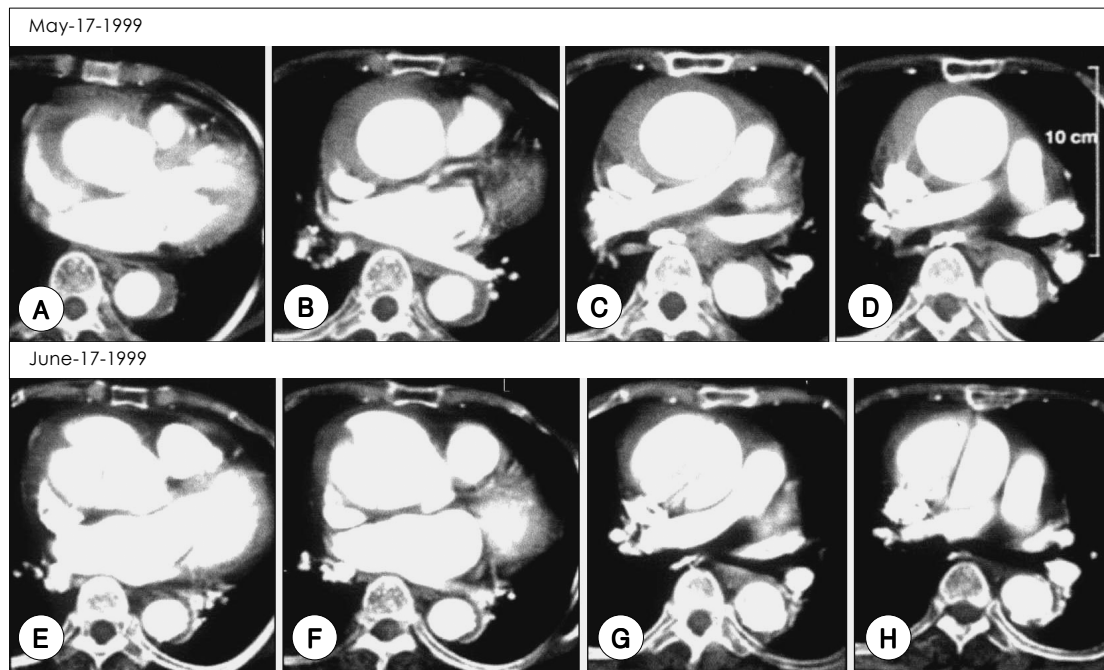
An example of development of typical aortic dissection in aortic intramural hematoma with medical treatment. At initial CT (A, B, C and D), crescentic wall thickening without contrast enhancement was observed. With medical treatment, the patient's condition stabilized rapidly, and she could be discharged with oral medication. One month after the initial event, chest pain redeveloped, and follow-up CT (E, F, G and H) revealed development of typical aortic dissection in the ascending aorta.
